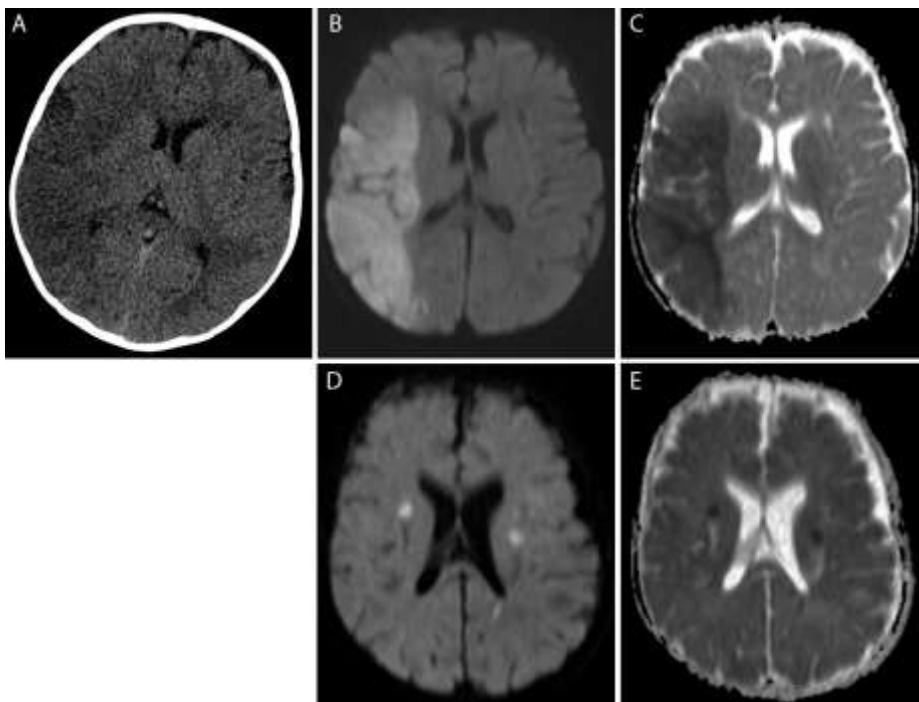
Vascular stroke patterns. A – C. Large vessel right middle cerebral artery (MCA) territory ischemic stroke. D- E. Small vessel ischemic infarcts. Hypodensity on axial CT (A) in the right MCA territory indicative of acute ischemic changes. Hyperintensity on axial DWI (B) and hypointensity on axial ADC (C), consistent with restricted diffusion in the right MCA territory indicative of an acute arterial ischemic stroke in this territory. Bilateral, punctate hyperintense DWI (D) and hypointense on ADC (E) lesions represent small vessel ischemic infarcts.
